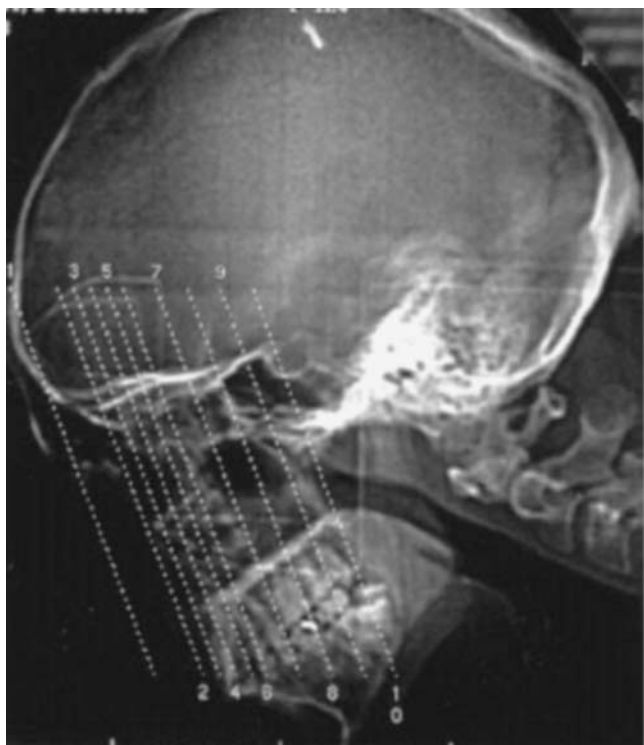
Scout view with different interslice gap between the 10 slices of the low-dose computed tomography protocol recommended for diagnosis of radiographic sinusitis. (Reproduced, with permission, from Hagtvedt T, Aalokken TM, Notthellen J, Kolbenstvedt A. A new low-dose CT examination compared with standard-dose CT in the diagnosis of acute sinusitis. *Eur Radiol.* 2003;13:976–980. With kind permission from Springer Science and Business Media.⁹¹)
